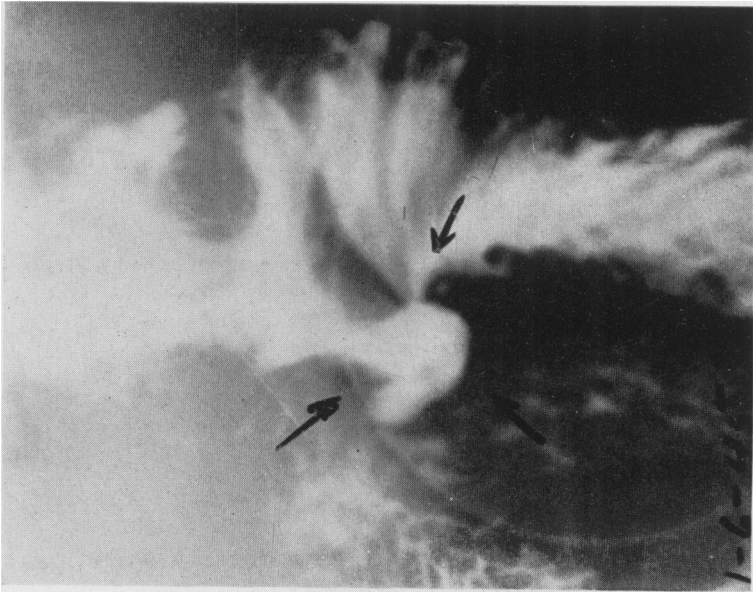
X-ray film showing a large gastrojejunal ulcer crater following antral exclusion and subtotal gastric resection.
